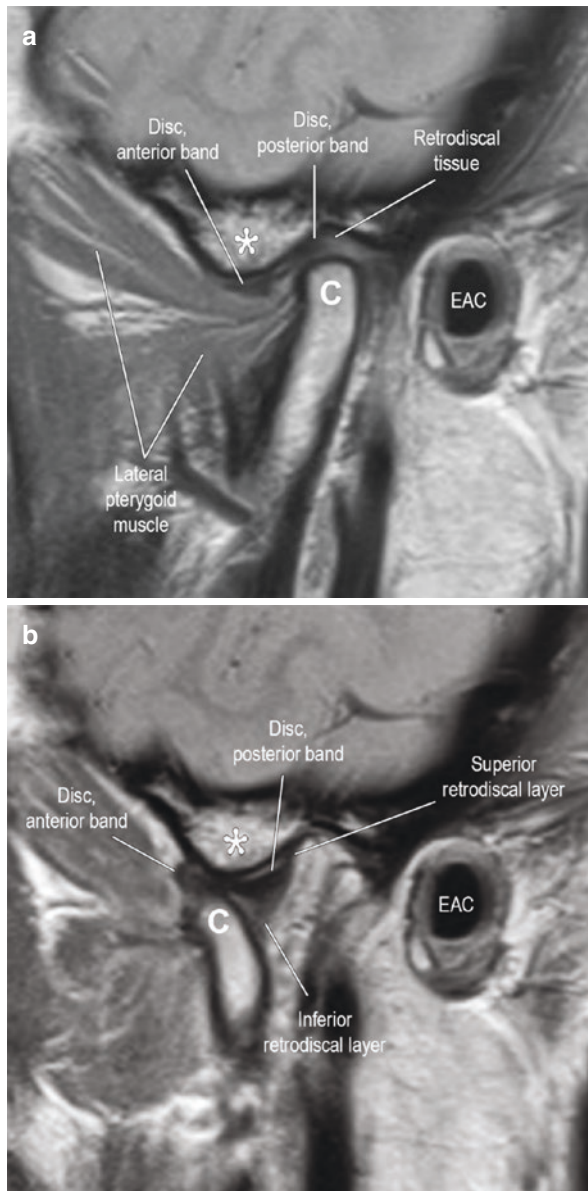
Normal TMJ anatomy on MRI. Closed mouth (a) and open mouth (b) sagittal PDW MR images demonstrate the normal appearance of the TMJ. On the closed mouth view (a), the mandibular condyle (c) is normally centered within the glenoid fossa, posterior to the articular eminence (indicated by the *asterisk*). The articular disc appears as an elongated, biconcave, homogeneously low signal intensity structure situated between the condyle and the articular eminence. On the open mouth view (b), the condyle rotates and translates anteriorly to rest in a position beneath the articular eminence. The disc slides anteriorly into a position between the condylar head and the articular eminence, assuming a configuration similar to that of a bow tie. The retrodiscal layers can generally best be seen on the open mouth views (EAC = external auditory canal)
